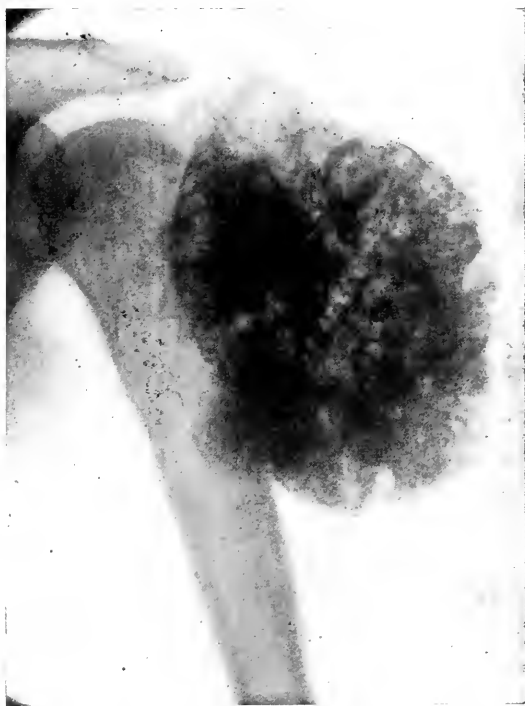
Roentgenogram taken before operation.
